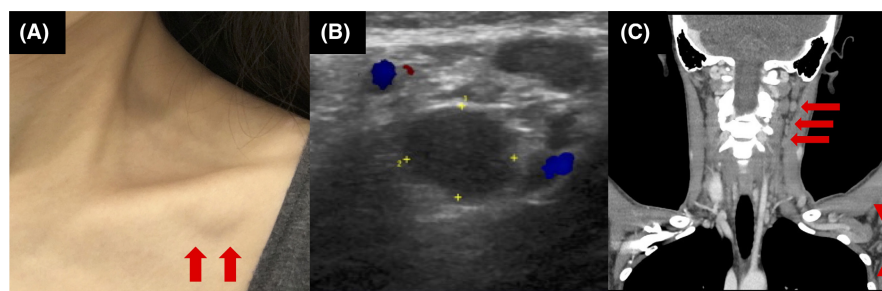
(A) Clinical appearance of the subcutaneous palpable nodule on her left upper clavicle (arrow). (B) Ultrasonography showing a rounded and hypoechoic lymph node without hilum. (C) Contrast-enhanced computed tomography showing not only axillary lymphadenopathies (arrow head), but also deep cervical lymphadenopathies (arrow) on her left sided
